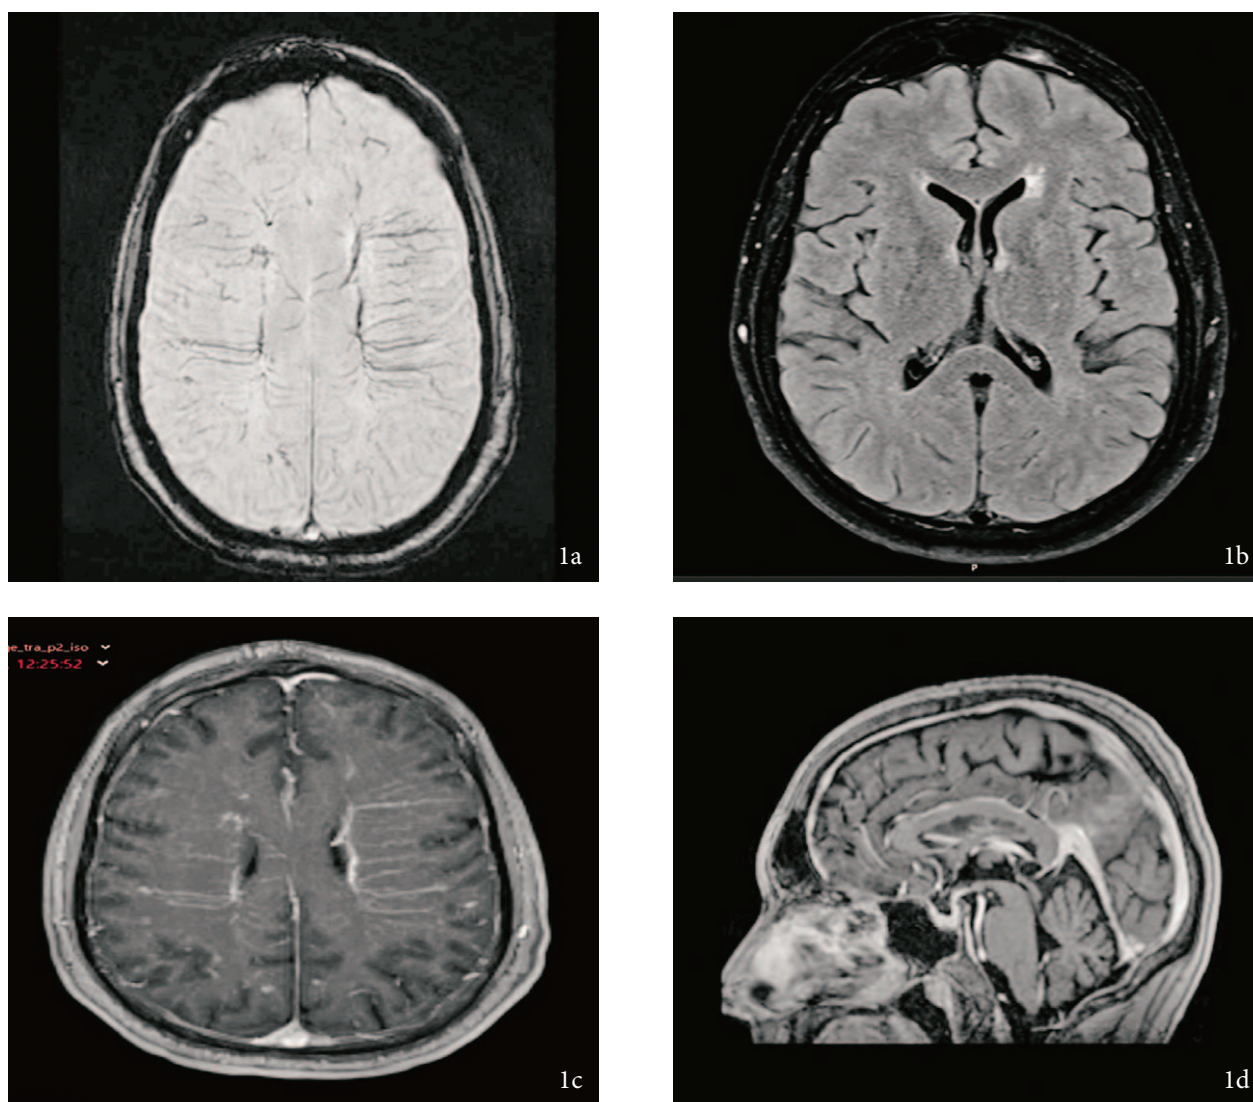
a) SWI MR shows multiple small subcortical areas of signal loss corresponding to microhemorrhage-related hemosiderin deposits and engorgement of medullary veins. b) T2/FLAIR sequence shows subcortical and periventricular hyperintensities. c) The contrast-enhanced T1-weighted MPRAGE sequence depicting diffusely dilated medullary veins. d) Sagittal plane – contrast-enhanced T1-weighted MPRAGE sequence shows contrast enhancement of the floor of the 3rd ventricle.
